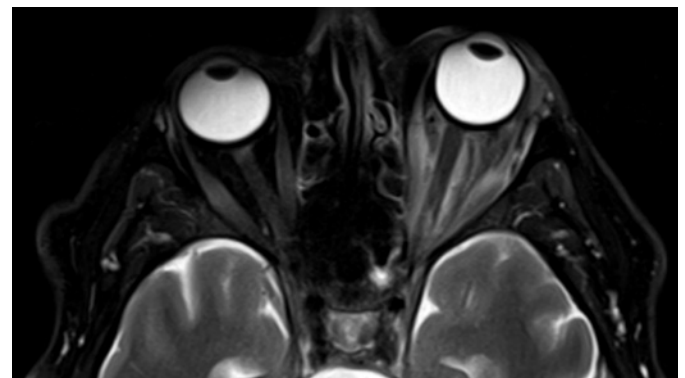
Axial T2-weighted magnetic resonance image of the orbits at 2 weeks, with improvement of the left superior ophthalmic vein thrombus and bilateral cavernous sinus thrombosis.
